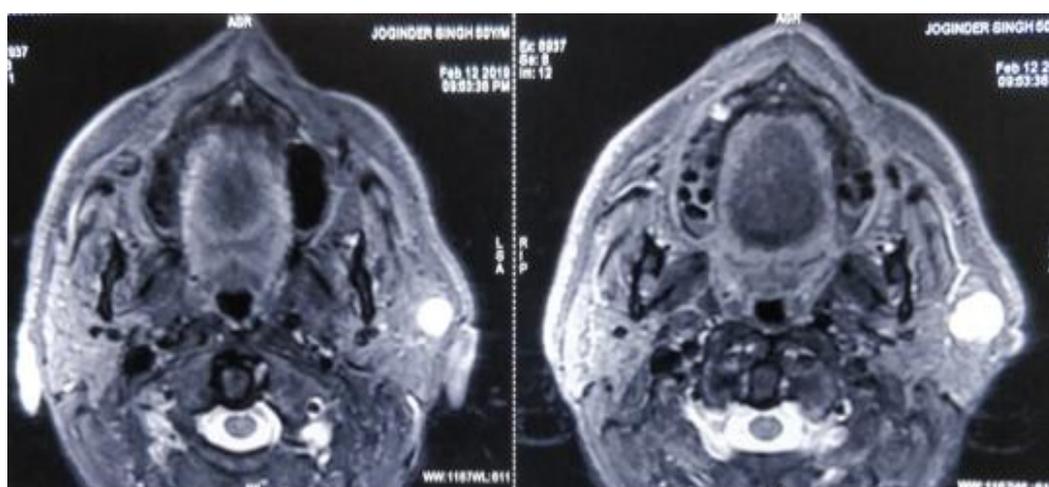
MRI face and neck, axial sections showing an oval altered intensity lesion in superficial lobe of parotid gland abutting facial nerve but not encasing or infiltrating it.
